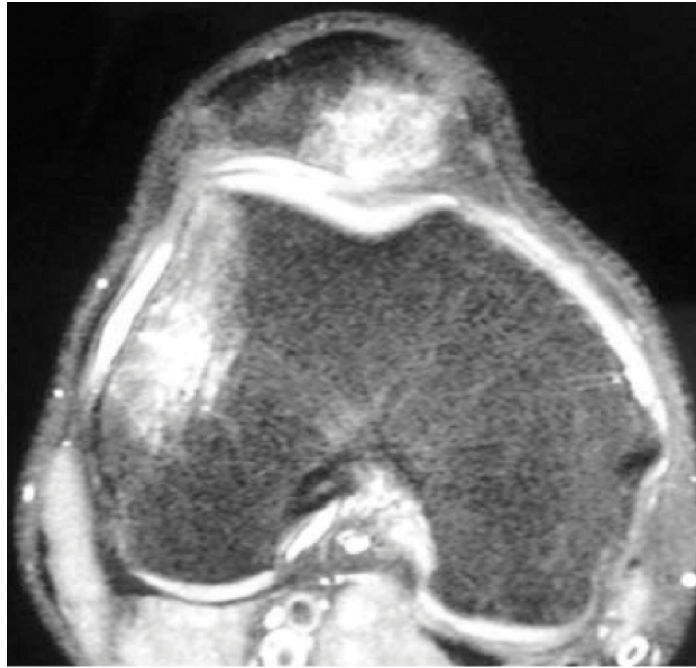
Axial view of a MRI of a right knee after patellar dislocation, showing an important bone bruise of the lateral edge of the trochlea and of the medial patellar ridge.
